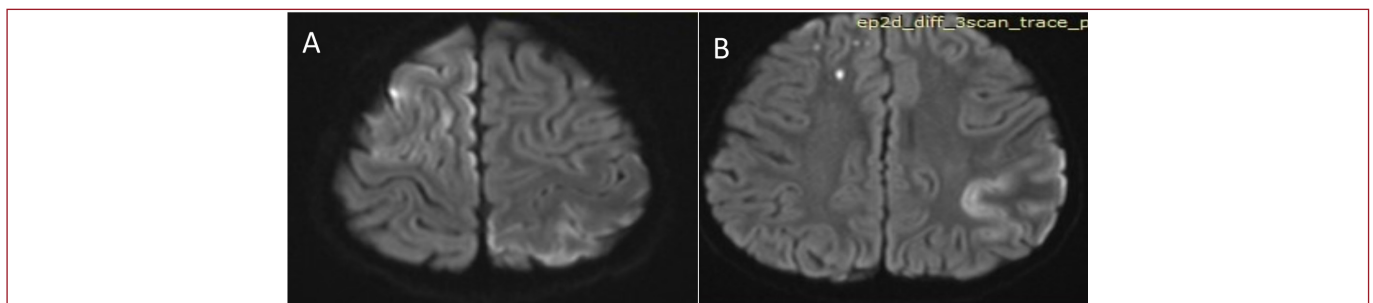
MRI Images (A,B) shows acute to subacute non-territorial infarct involving right frontal and left parieto-occipital region.
